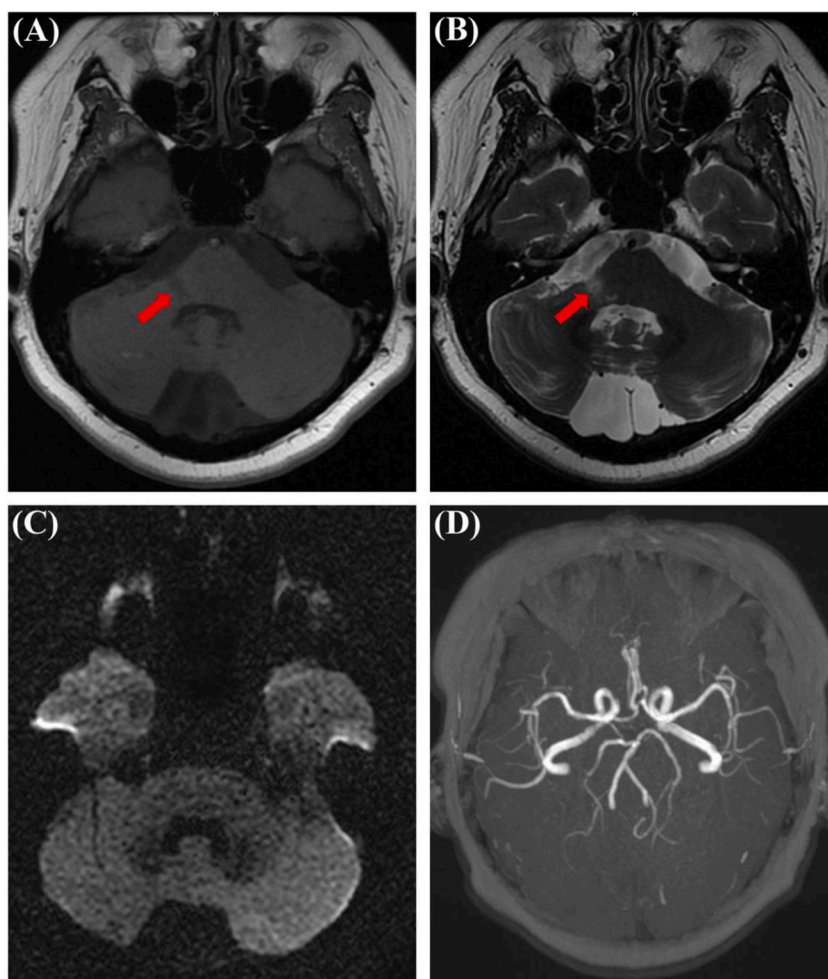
The brain MRI images showed a subacute infarction located in the dorsolateral to the right pons. (A, B). A lesion with hypo-intense signal or moderated-intense signal (red arrowhead) located in the dorsolateral to the right pons was revealed by T1 (A) or T2-weighted MRI (B), respectively. (C). Brain diffusion-weighted image showing no signs of acute pontine infarction. (D). MRTA shows no vertebrobasilar artery main trunk occlusion or stenosis.
